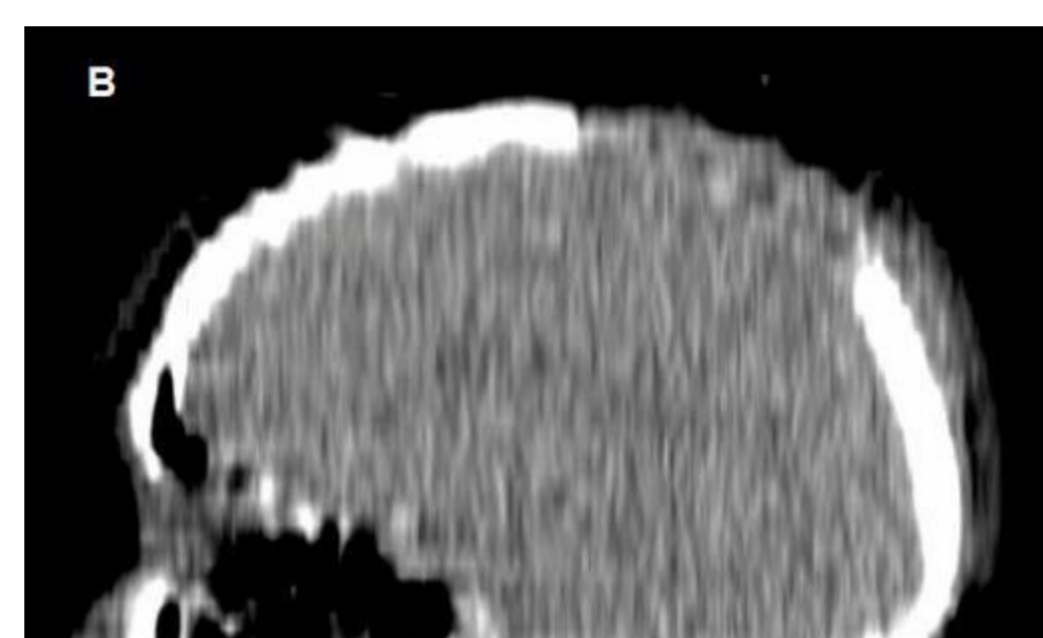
Figure (A) kV CT; (B) MV CT.
